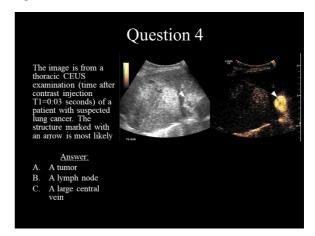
Example of a final multiple-choice question. Designed with one single best answer (C) and two distractors. The learner must know the distribution phases of intravenously injected ultrasound contrast agents to correctly answer this question. Item difficulty and point biserial discriminatory index were 0.68 and 0.29, respectively. CEUS = contrast-enhanced ultrasound.
